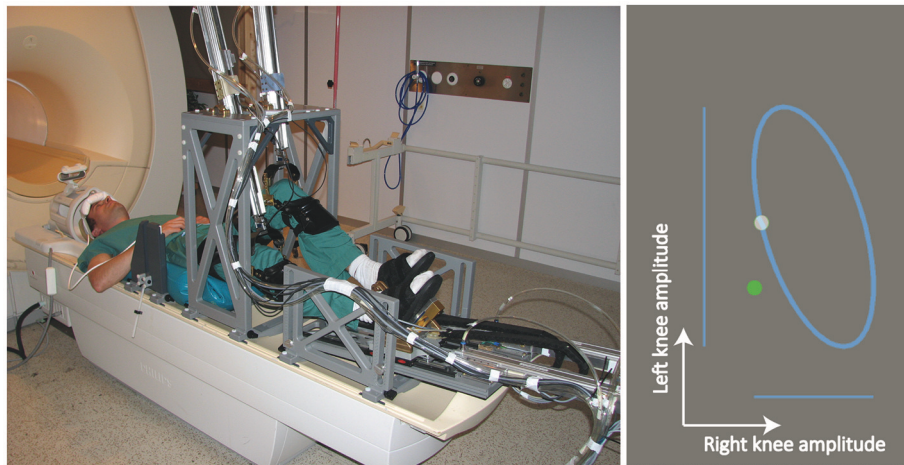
(Left) The MRI-compatible robotic stepping actuator MARCOS in the 1.5 Tesla MR scanner (Hollnagel et al., 2011). The participant in this figure consented to the publication of his image. (Right) The Lissajous figure visually presented to participants. Subjects were requested to track a white dot that moved on top of a Lissajous figure by coordinating the legs in a predefined gait-like pattern. Subjects tracked the white dot with a green dot that moved up and down when the left leg moved up and down, and moved right and left when the right leg moved up and down.
